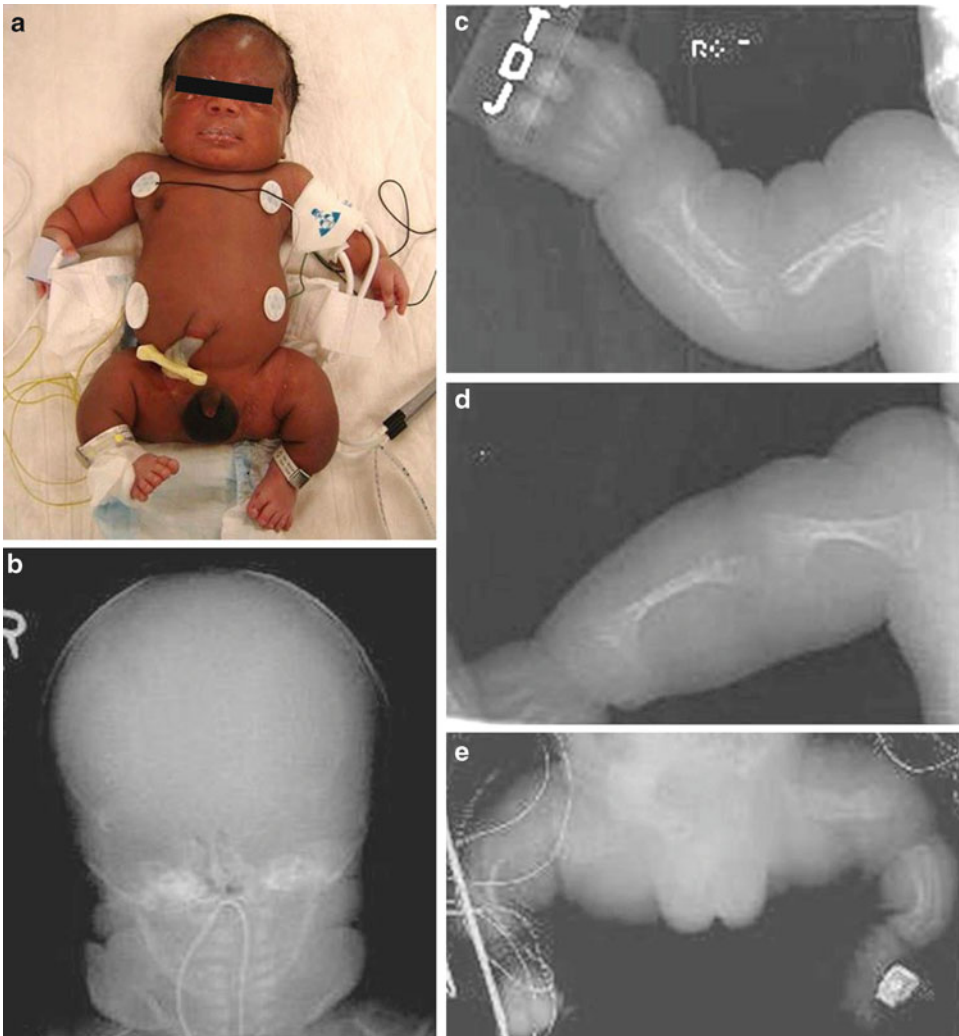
(a–e) A neonate with osteogenesis type III showing short-limbed dwarfism, large head, short neck, short thigh, and curbed lower legs. Radiographs showed generalized osteopenia; poor mineralization of the skull; thin ribs with sixth, seventh, and eighth rib fractures with callus formation; short limbs; and bowed femurs with multiple fractures
